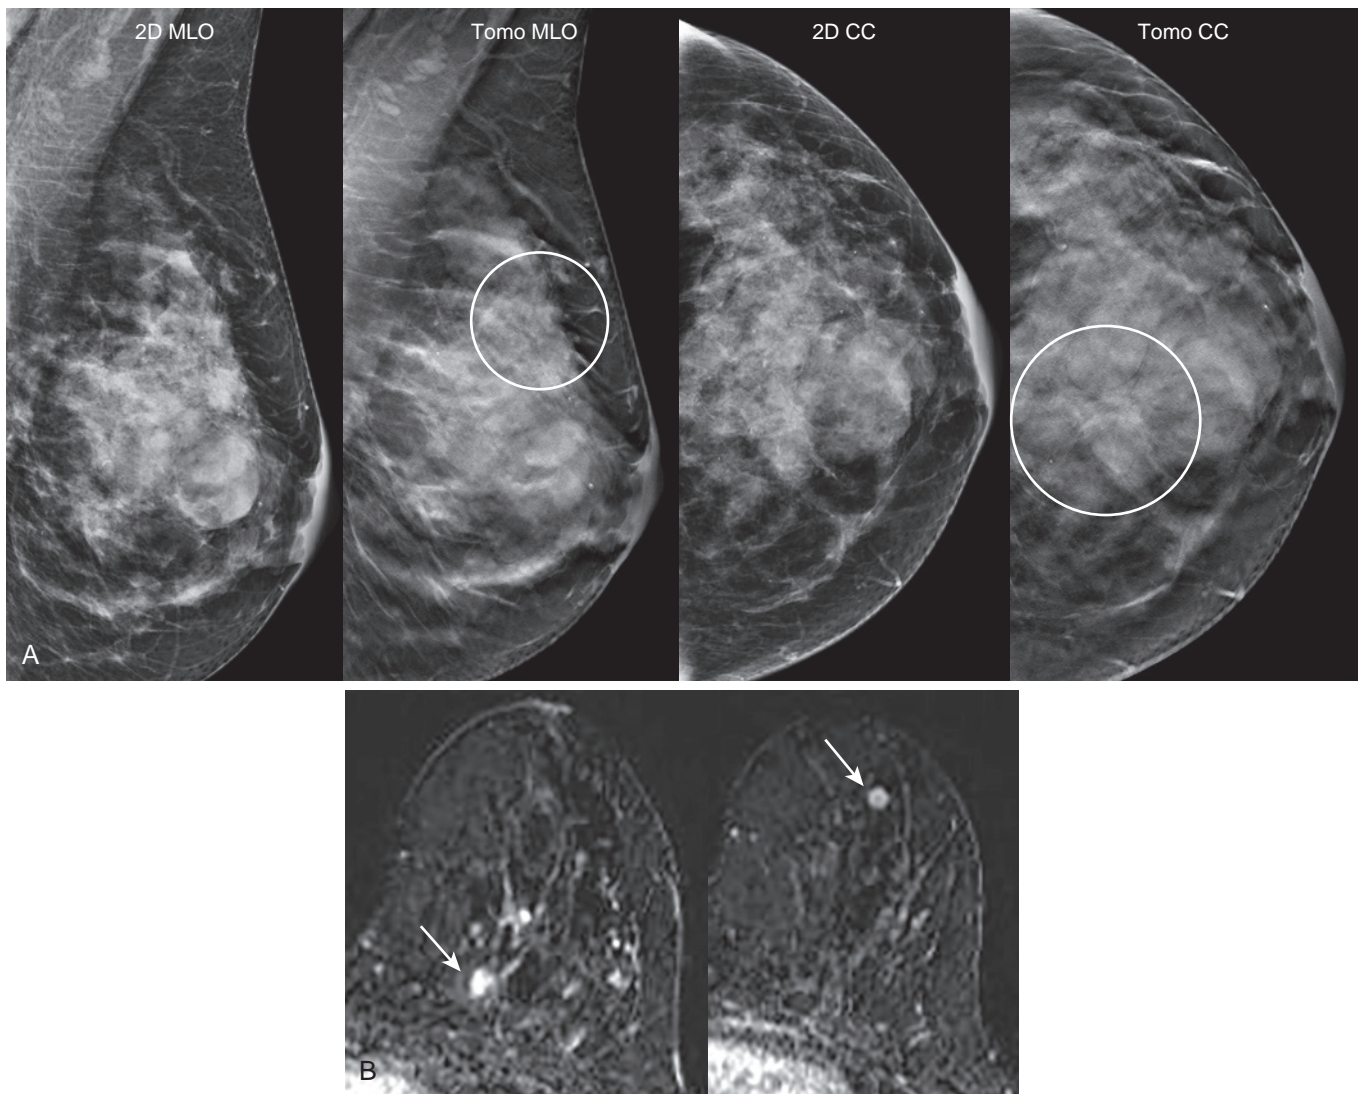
Malignant architectural distortion confirmed with magnetic resonance imaging. (A) A 12-month follow-up bilateral diagnostic mammogram in a 52-year-old average risk woman being followed for probably benign calcifications in the right breast (not shown). Tomosynthesis reveals a subtle left AD best seen on the MLO view and thought to be in the upper breast (circles). Targeted ultrasound was normal. Because the AD was large, a new MRI was recommended. (B) Axial fat-suppressed T1WC+ MRI revealed two suspicious enhancing lesions in the left breast (arrows). The more posterior lesion was thought to possibly correspond with the mammographic finding. MRI-directed ultrasound was normal, and MR biopsy was performed. MRI-guided core needle biopsy posterior lesion = atypical lobular hyperplasia and a radial sclerosing lesion. MRI-guided core needle biopsy anterior lesion = classic LCIS and sclerosing adenosis. Surgical excision of both sites was performed, revealing the posterior lesion to be a radial sclerosing lesion and a 9 mm IDC, grade 1, ER/PR+, Her2-, 0/7 SLN. The anterior lesion proved to be benign.
